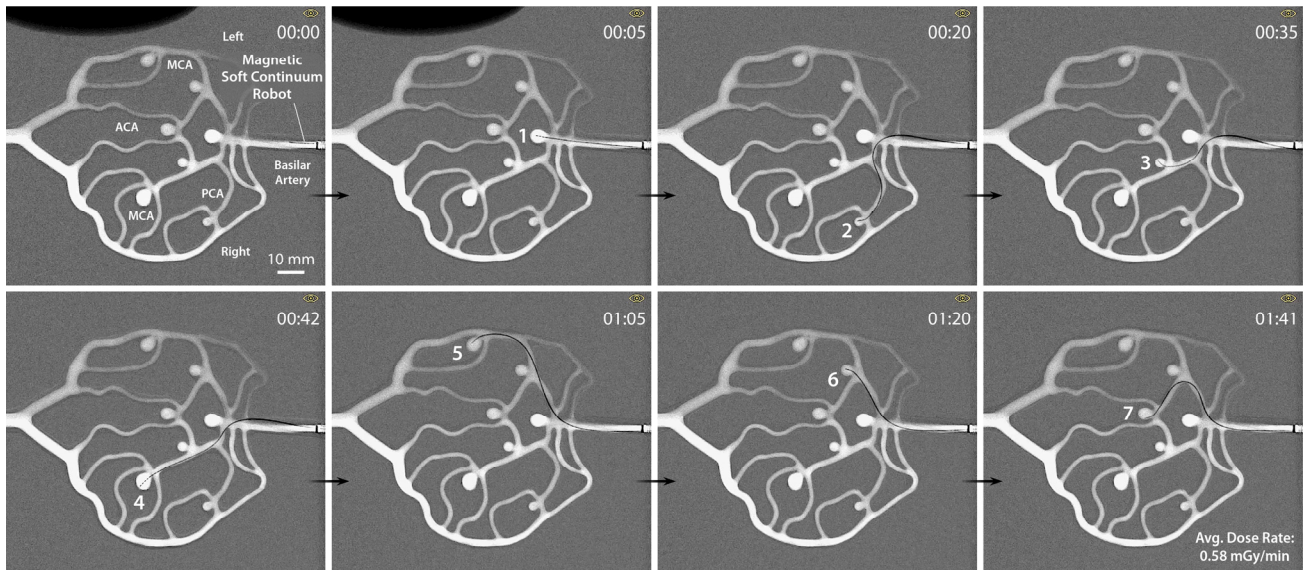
Magnetic soft continuum robot selectively reaching the aneurysms present in the 2D neurovascular model under real-time teleoperation of the developed system for spatial positioning of the actuating magnet relative to the steerable tip of the magnetic soft continuum robot to utilize either attractive or repulsive steering in the model vasculature under x-ray fluoroscopy.
